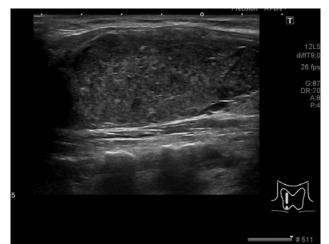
Gray scale image of a 35 year old patient with hypothyroidism and raised TPO-Ab levels. Ultrasound showed an enlarged thyroid riddled with tiny hypoechoic nodules (micronodulation).
